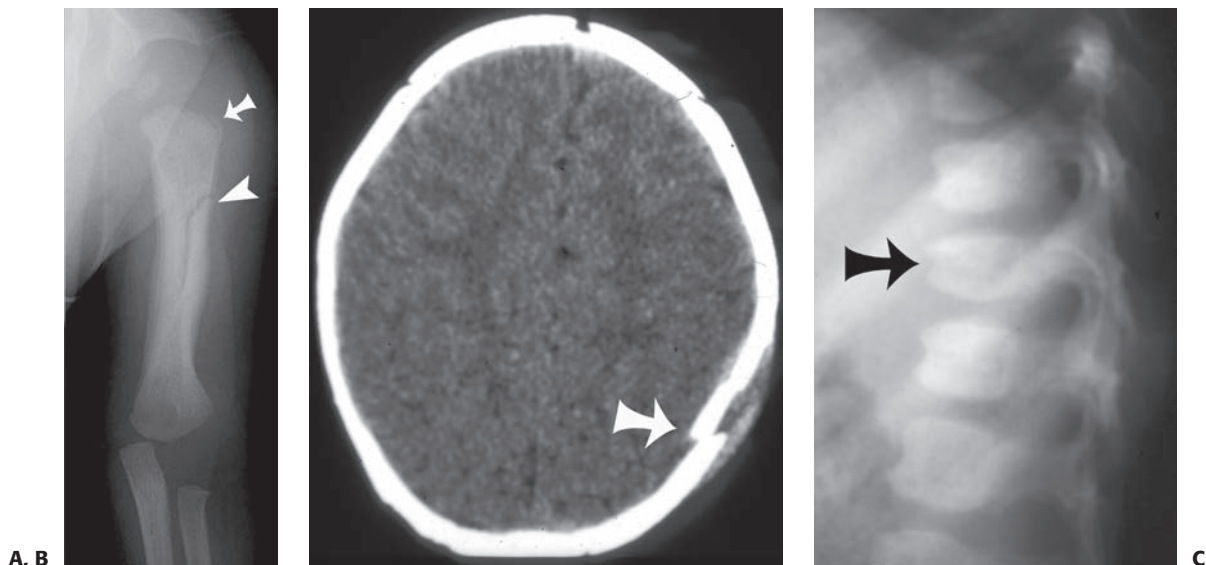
Multiple fractures in a 3-month-old female victim of inflicted injury. A: Frontal radiograph of the humerus shows proximal metaphyseal irregularity consistent with a corner fracture (*arrow*) and an oblique diaphyseal fracture with extensive periosteal reaction and healing (*arrowhead*). B: Axial CT image reveals a depressed left calvarial fracture (*arrow*). C: Lateral thoracolumbar radiograph suggests a T12 compression fracture (*arrow*), which is confirmed on nuclear bone scintigraphy (D) as a region of increased uptake (*arrow*). Bone scan also confirms left parietal (*arrowhead*) and humeral (*curved arrow*) fractures.
